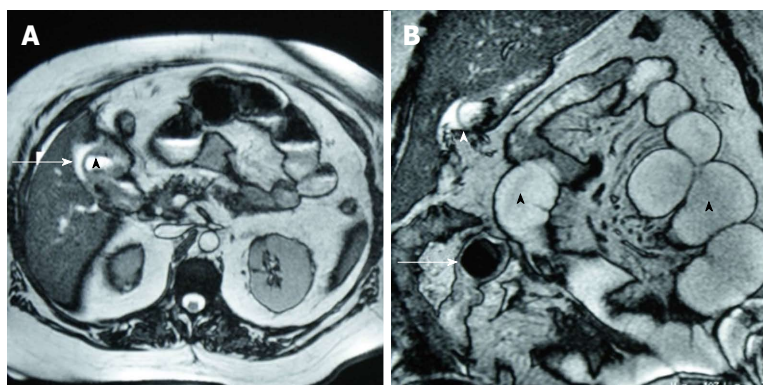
Magnetic resonance cholangiopancreatography findings in a patient with gallstone ileus. A: On T2-MRI, a hyperintense image is identified in the gallbladder bed (arrow), with communication with the duodenal second portion (arrowhead), suggestive of a cholecystoduodenal fistula; B: MRI coronal reconstruction showed dilated small bowel loops with endoluminal air (black arrowheads) and a signal-void round-shaped image, suggestive of a gallstone (arrow). Gallbladder communication with duodenum is observed (white arrowhead). MRI: Magnetic resonance imaging.
